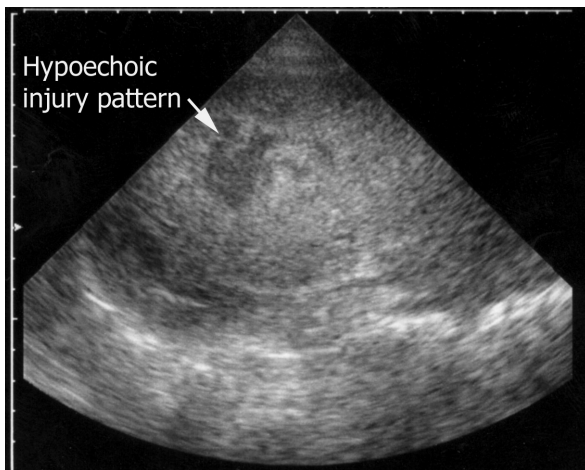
Ultrasound image of a solid organ injury seen as a hypoechoic region within the parenchyma.
